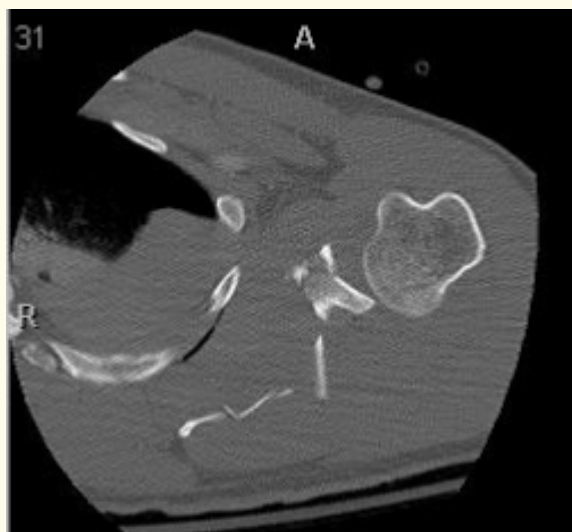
Pre-operative radiographs of patient #2 with complex scapular fracture and posterior glenohumeral subluxation.
